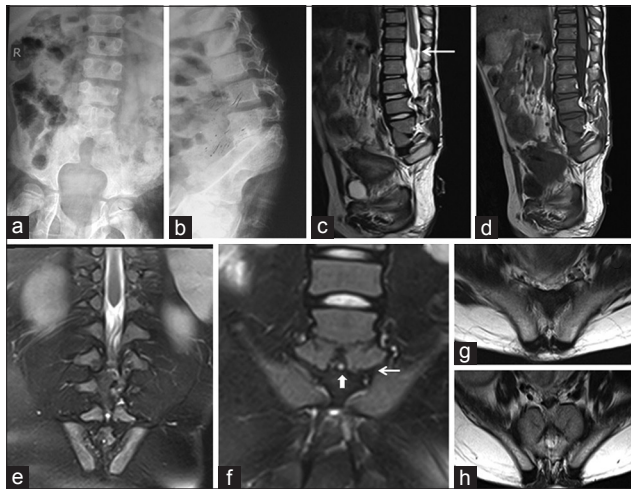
A 9-year-old male child with fecal incontinence, (a) and (b) X-ray anteroposterior and lateral views of lumbosacral spine shows the absence caudal spine with midline cleft in the lower lumbar vertebra. (c) Sagittal T2-weighted image, (d) T1-weighted image, and (e) coronal short-tau inversion recovery images show a complete absence of sacrococcygeal segments with a fusion between L4 and L5 vertebrae and wedge-shaped conus (← arrow) terminating at D12 vertebral level. (f) Coronal short-tau inversion recovery and (g and h) axial T2-weighted images show articulation in between iliac bones with L5 vertebra (← arrow) with a sagittal cleft in L5 vertebral body (↑ block arrow) representing Type I caudal regression syndrome.
